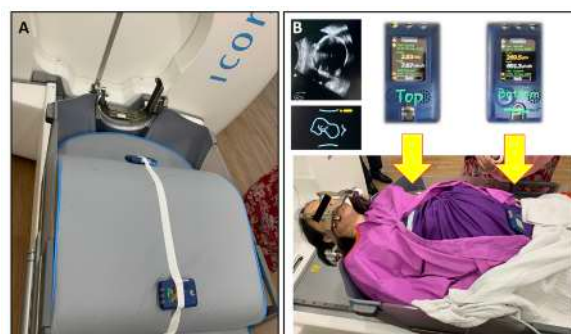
A) Trial run by placing dosimeters at the top and bottom parts of a foam knee support at a distance that mimicked the patient with gravid uterus to predict radiation exposure. B) Dosimeters placed near uterine fundus and suprapubic region (consistent with concomitant ultrasound localization of fetal head) during actual treatment recorded the actual extracranial dose exposure, which were 2.83 mSv and 0.270 mSv respectively.
